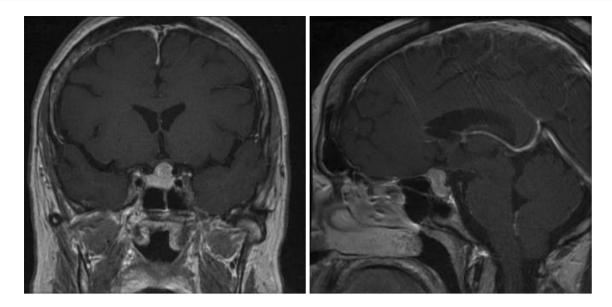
Pre-operative coronal (*left*) and sagittal (*right*) post-gadolinium T1-weighted magnetic resonance imaging of anterior skull base meningioma
